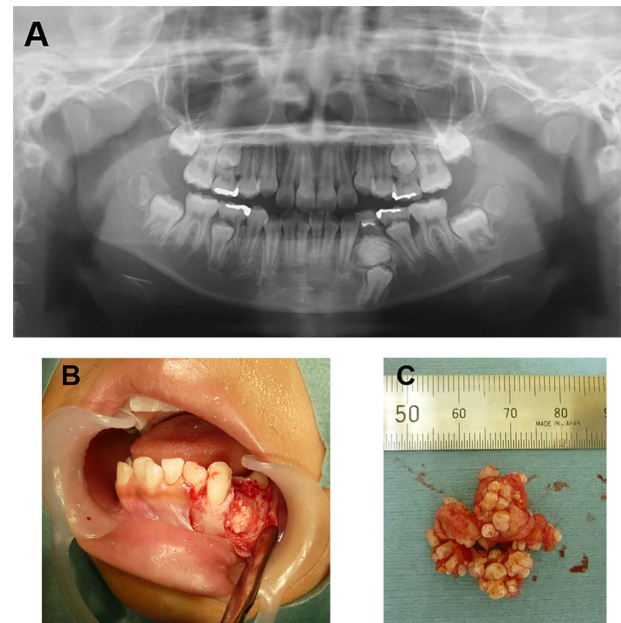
(a) The orthopantomogram depicts the over-retained left deciduous mandibular first molar; a circular, well-defined radiopacity apical to this primary tooth; and the impacted left mandibular first premolar immediately below the lesion. (b) Intra-operative photo: an incision was made in the buccal gingiva, a mucosal periosteal flap was raised and cortical bone was removed to reveal the lesion. (c) Excised material: the odontoma is an aggregate of small, tooth-like masses.
